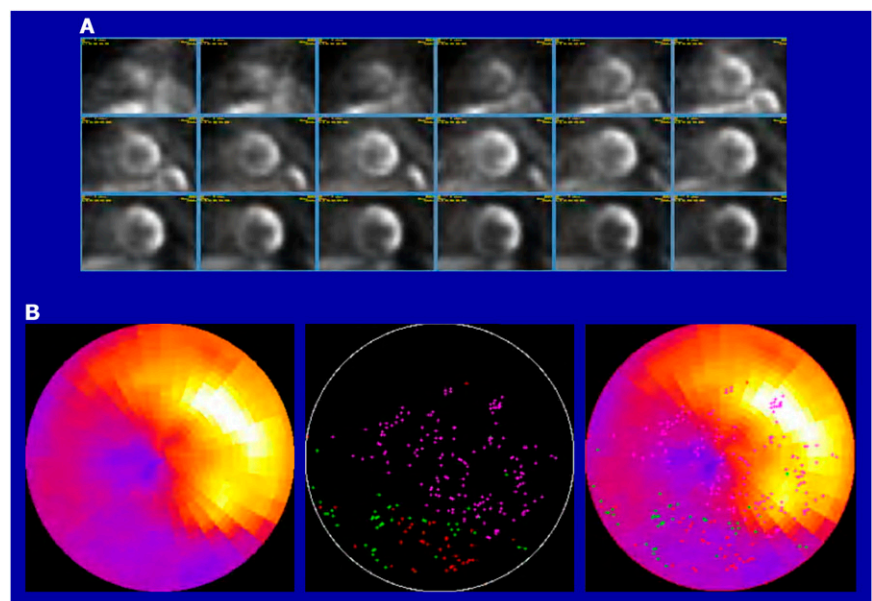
Registration and fusion of cardiac electrophysiology voltage measurements with myocardial PET studies. A. Short-axis FDG PET slices. B. Polar plots of: (left) $^{18}\text{F-FDG}$ viability, (middle) discrete electrophysiologic (EP) voltage points (pink = normal [> 1.5 mV]; green = border zone [0.5 – 1.5 mV]; red = scar [< 0.5 mV]), (right) fused PET/EP image.
